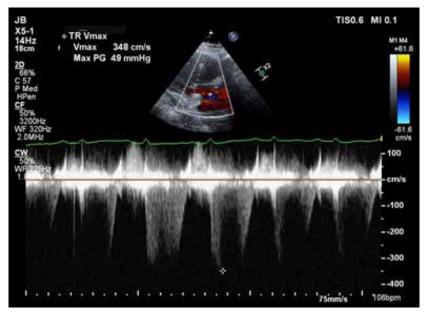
Pre-operative transthoracic echocardiography estimated elevated pulmonary artery pressures by utilizing tricuspid regurgitant spectral Doppler jet
